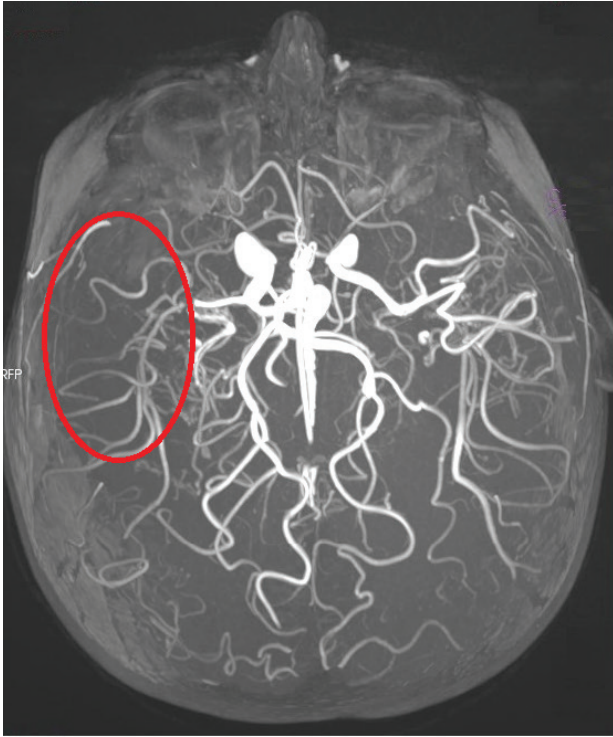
Cranial magnetic resonance imaging of case 9. Severe stenosis from the distal of the right middle cerebral artery M1 segment in 3D image and poor filling compared to its symmetry.
